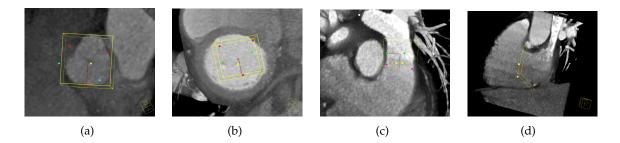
Examples of the anatomical landmark motion estimation in cardiac CT: (a) aortic valve, (b) mitral valve, (c) pulmonary valve, (d) tricuspid valve. The colored points are showing the landmarks for each valve.
